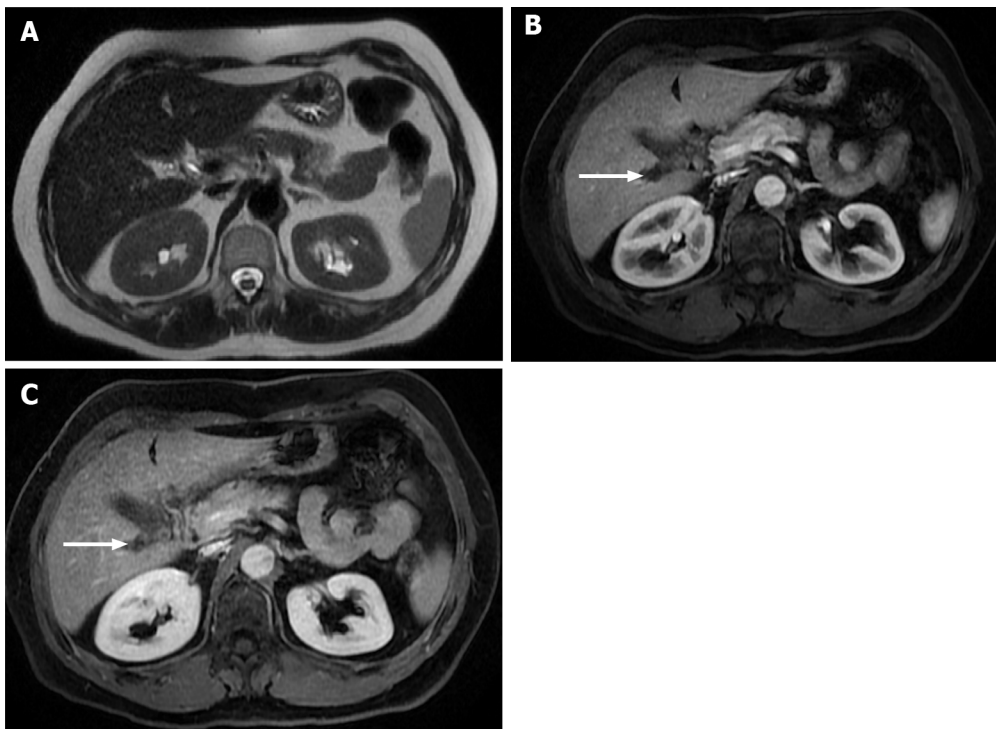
Follow-up of a 66-years-old woman with previous breast cancer liver metastases submitted to chemotherapy showing complete response in 2015. A: Axial T2-weighted imaging (WI) shows the liver metastasis characterized by an isointense lesion; B and C: Axial fat sat contrast-enhanced magnetic resonance imaging T1-WI in the arterial (B) and interstitial (C) phases present the liver metastasis without noticeable enhancement in the post-contrast dynamic study (arrow, B and C), which is consistent with treated metastasis (no viable tumor). To date, after 6 years, the patient is free of recurrent disease.
